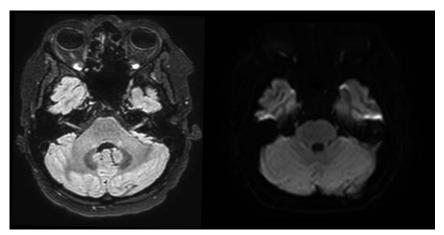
No cerebellar atrophy, infarction, tumor, diffusion restrictions, or signal changes were shown on MRI (left panel, transversal fluid-attenuated inversion recovery image at the level of the cerebellum; right panel, transversal diffusion-weighted image at the same level). A diagnostic CT of the thorax and abdomen (not shown) demonstrated enlarged axillary lymph nodes, but no primary tumor. Puncture of these nodes showed non-small cell carcinoma. In combination with the clinical signs, a paraneoplastic syndrome induced by an occult breast or lung cancer was considered, and consequently, ¹⁸F-FDG PET/CT imaging was performed from the skull extending to the groin. The PET/CT scan suggested an occult breast carcinoma (not shown), which was confirmed by pathological examination. It also showed cerebellar hypermetabolism (see Figure), consistent with a paraneoplastic cerebellar syndrome (PCS). Finally, anti-Yo antibodies were detected, which are related to the presence of breast cancer. At first, the patient was treated with methylprednisolone for 5 consecutive days, with improvement of symptoms. Second, when the symptoms increased a few days later, a 5-day IV immunoglobulin treatment was started. Finally, the patient received a combination of pertuzumab, trastuzumab, paclitaxel, and carboplatine followed by surgery, as a therapy for breast carcinoma. Unfortunately, after 3 months, neurological examination showed no improvement compared with the patient's first admission. Clinically, an acute cerebellar syndrome may occur as a PCS, and scintigraphically as diffuse cerebellar hypermetabolism. At an early disease stage, structural brain imaging is commonly normal. The neoplasms most commonly involved are small cell lung cancer, gynecological (including carcinoma of the fallopian tube) and breast tumors, and Hodgkin lymphomas, ^{1–5} but it is also described in, for example, carcinoma of the tonsil, gastric adenocarcinoma, and extragonadal germ cell tumors. ^{6–8} An acute cerebellar syndrome is one of the most common neurological paraneoplastic syndromes and is most likely immune mediated. Indeed, frequently, antineural antibodies in the cerebrospinal fluid and/or serum can be demonstrated. In PCS, an extensive loss of Purkinje cells might be associated with inflammatory infiltrates in the cerebellum.¹ Cerebellar hypermetabolism is not exclusive for PSC. Interestingly, a recent study also showed intense cerebellar hypermetabolism, demonstrated by ¹⁸F-FDG PET, in a case with leptomeningeal metastasis associated with an atypical meningioma. The cerebellar metabolism in that particular case is similar to that of our present case; however, cerebellar antibodies such as anti-Yo are not detectable in patients with leptomeningeal metastasis, and clinically PSC can frequently be differentiated leptomeningeal metastases. Also, a recent study showed relatively cerebellar hypermetabolism in patients experiencing amyotrophic lateral sclerosis with frontotemporal dementia. However, in these patients, the cerebellar hypermetabolism is less pronounced than in PCS.¹⁰ This case shows that ¹⁸F-FDG PET imaging may be of value in patients in which a PCS is considered, particularly in patients suspicious for an occult malignancy or in which the primary tumor is not detected after routine examinations.
